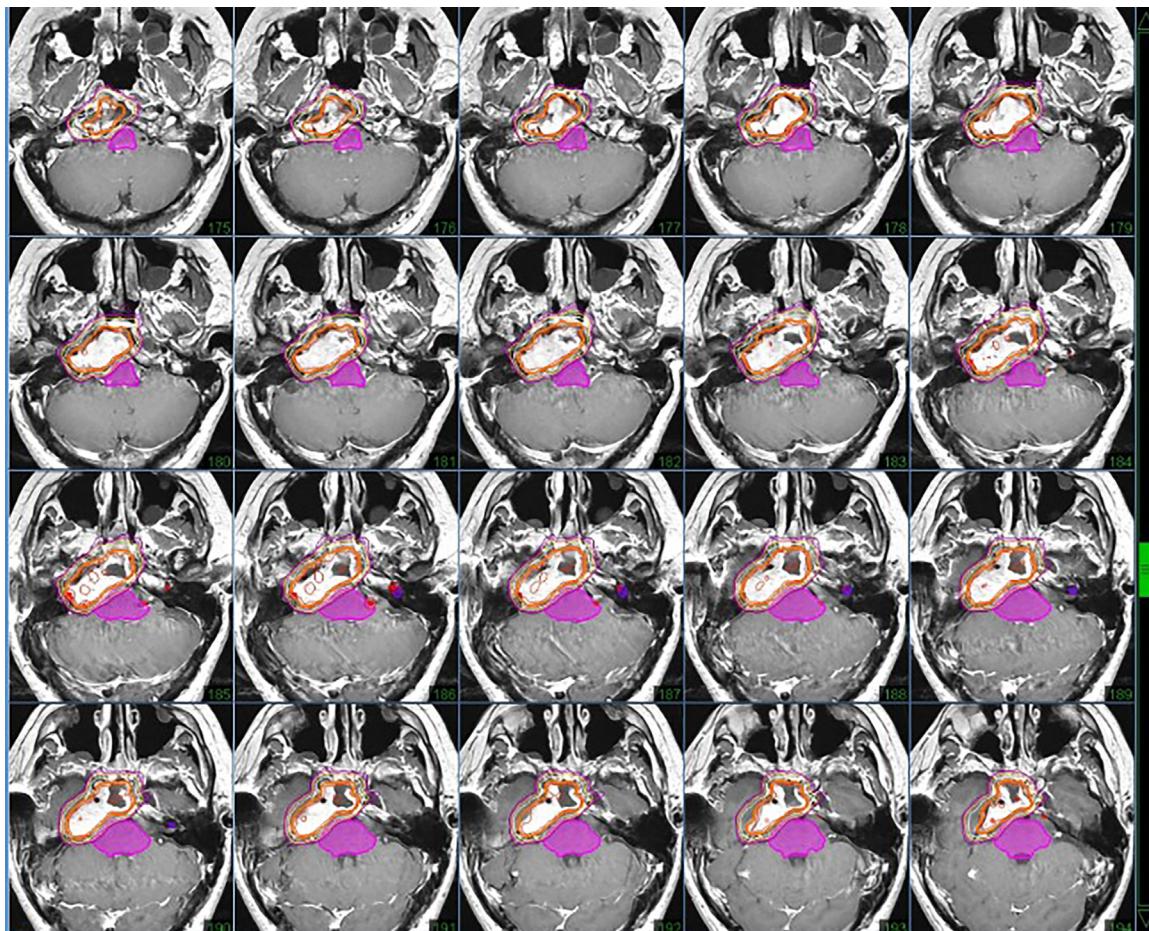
Magnetic resonance images fusion with CT planning scan for tumour targeting.
